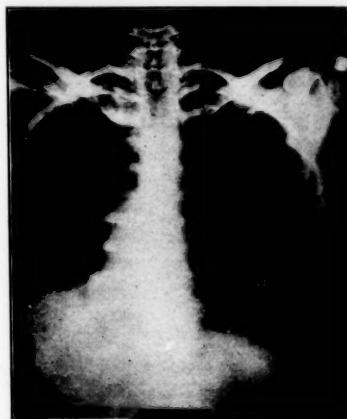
(Case III.) Condition 24 hours postoperative. Right lung involved only at the base but the heart much displaced to the right. Subsequent roentgenograms showed no further involvement until onset of broncho-pneumonia.
